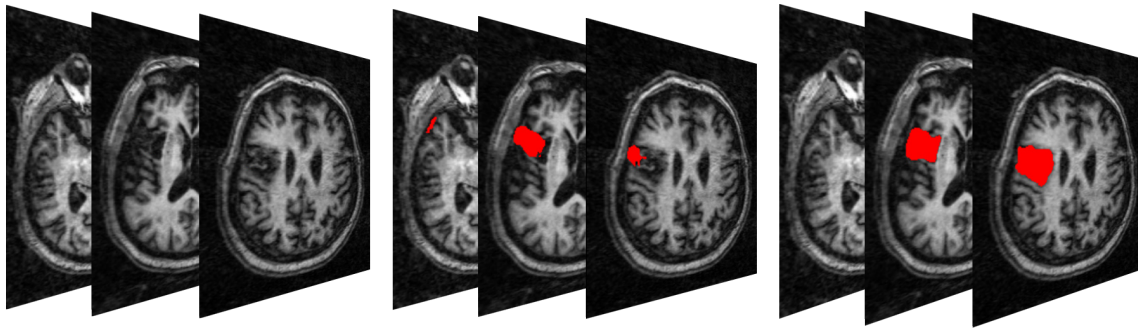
MRI scan used in parameter testing: left – original, middle – best DSC region grown, right – hand delineated region.
